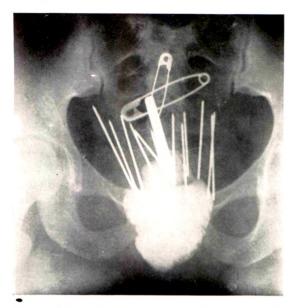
Roentgenogram showing needles and capsule in place. Dense area shows iodoform packing in vagina. (Courtesy of Surgery, Gynecology and Obstetrics.)
